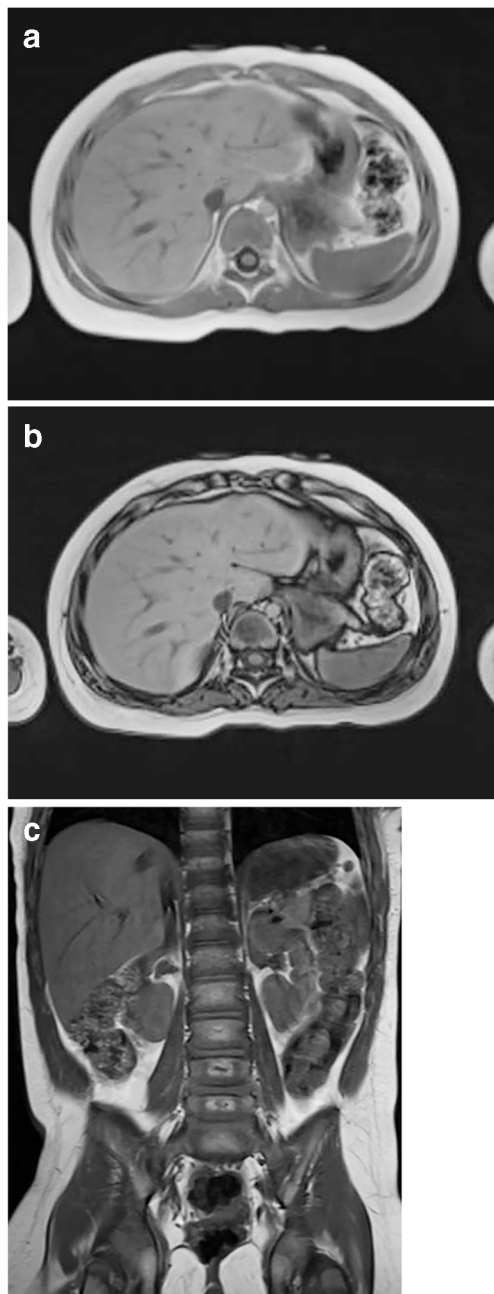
A 3-year-old girl post resection of a right retroperitoneal neuroblastoma. a, b In-phase (a) and opposed-phase (b) images from StarVIBE (volumetric interpolated breathhold examination) Dixon with quality scores of 5 across all metrics by both readers. c A traditional study performed 6 months earlier consisted of a coronal T1-weighted turbo spin echo sequence with a mean overall quality score of 3, mean hepatic vessel sharpness score of 3, mean motion robustness score of 3 and mean hepatic edge sharpness score of 3.5
